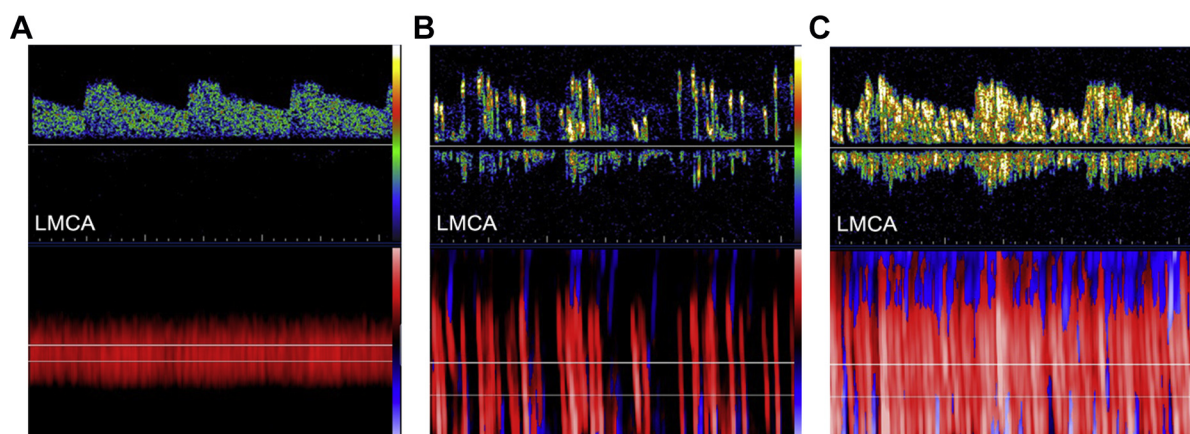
Contrast transcranial Doppler ultrasonography in left middle cerebral artery showed (A) blood flow signal without agitated saline injection, (B) several microbubble signals in normal respiration, and (C) considerable microbubble signals with Valsalva maneuver. LMCA = left middle cerebral artery.
